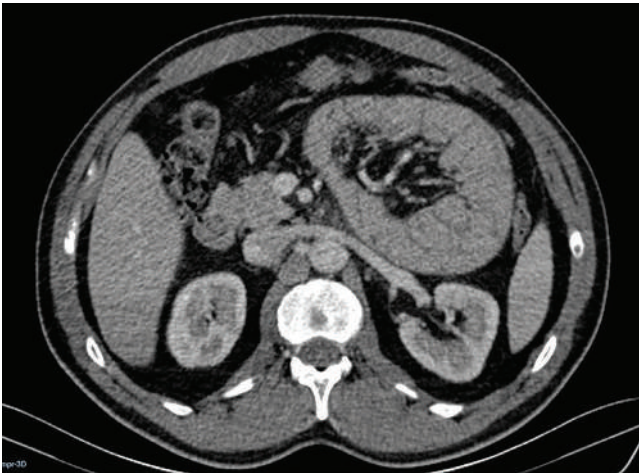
Contrast-enhanced CT: Closed-loop obstruction of jejunal loops with findings suggestive of internal hernia.
